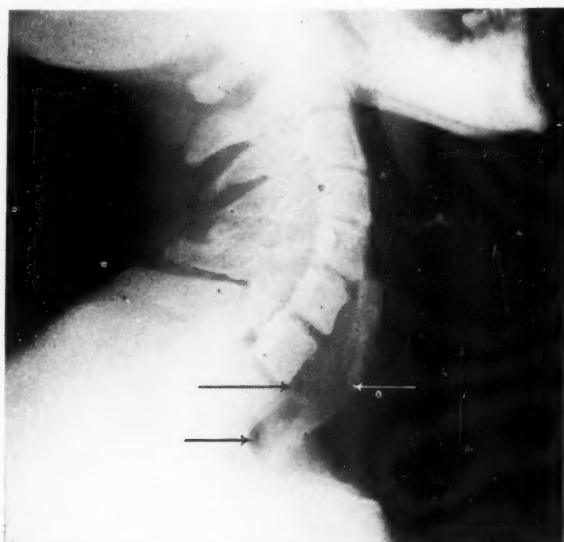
Case 1: Roentgenogram showing the tumor of the first portion of the cervical esophagus.
